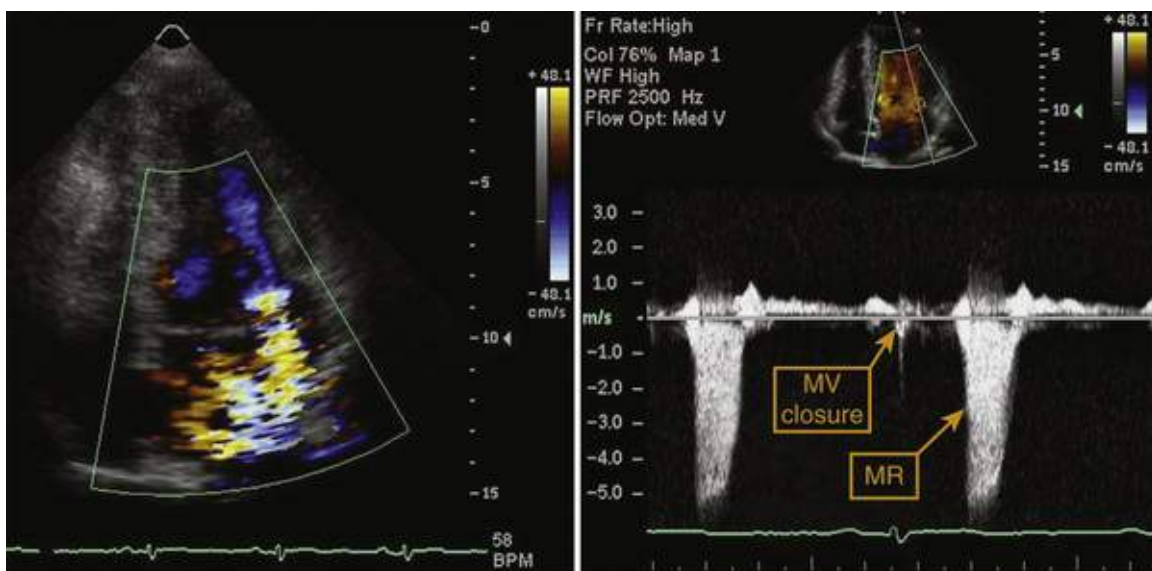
Limitation of the proximal isovelocity surface area (PISA) method when mitral regurgitation (MR) is not holosystolic. Although there is a large proximal convergence zone with an effective regurgitant orifice area (EROA) of 0.6 cm^2 (left panel), the continuous-wave Doppler (CWD) pattern (right panel) demonstrates that the regurgitation does not begin until the latter half of systole, which is very common in mitral valve (MV) prolapse. Thus the regurgitation is much less severe than a single frame showing the largest jet, vena contracta, or convergence zone would imply. When calculating regurgitant volume, one should multiply EROA by the velocity time integral (VTI) from the dense part of the CWD signal, not including the faint, early systolic portion when MR is mild.
